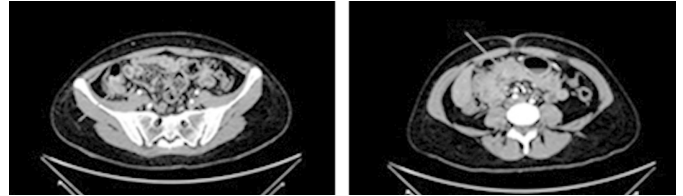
CT hyperdensity area in the lumen.
